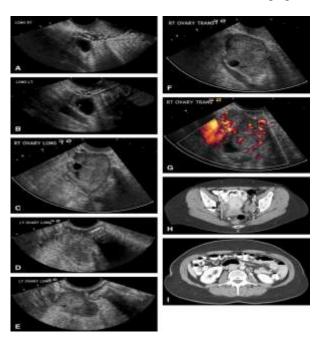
A 53-year-old woman with a family history of ovarian and breast cancer developed bilateral stage III high-grade papillary serous ovarian cancer with a 6-month interval between ultrasound examinations. (A and B) Ultrasound revealed bilateral simple follicles, normal-sized
